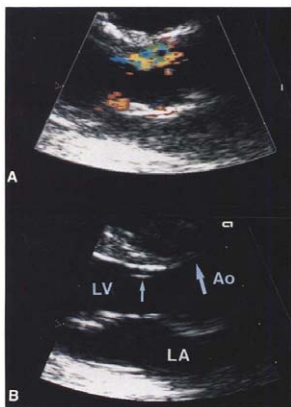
A, Systolic color flow map shows variance in the anterior part of the subaortic region. Flow in the posterior part was mapped from more obtuse angles and found to be laminar. B, The two-dimensional echocardiogram identifies a small ridge (small arrow) as a cause of the flow separation. In this patient no ventricular band could be related to the ridge. Large arrow = insertion of the right coronary aortic (Ao) cusp. Other abbreviations as in Figure 1.
